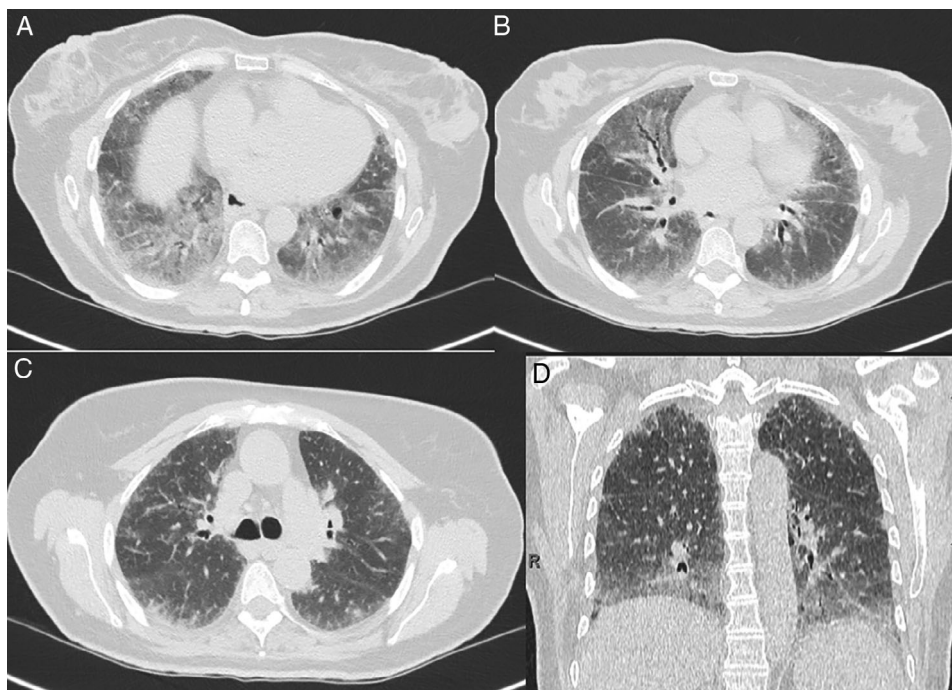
(A) Sagittal plane in chest computed tomography (CT) scan with pulmonary window: ground-glass opacities with predilection for middle and mainly lower lung zones. (B) Axial CT septal thickening more obvious in the upper zones. Sagittal (C) and axial (D) chest CT scan with pulmonary window and minimum intensity projection (MiniP): traction bronchiectasis in middle lobe (ML) and lingula.
